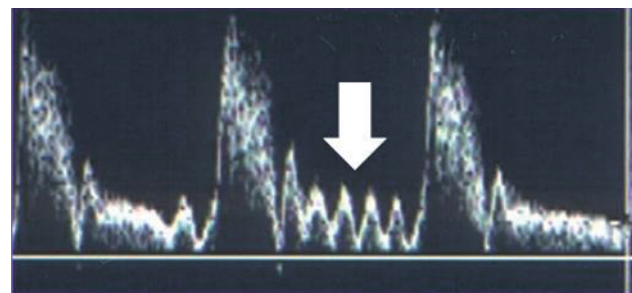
Tapping the superficial temporal artery produces reverberations (arrow) in the external carotid-artery waveform. This can sometimes help distinguish the internal from the external carotid artery during duplex-ultrasound studies of the carotid bifurcation.
